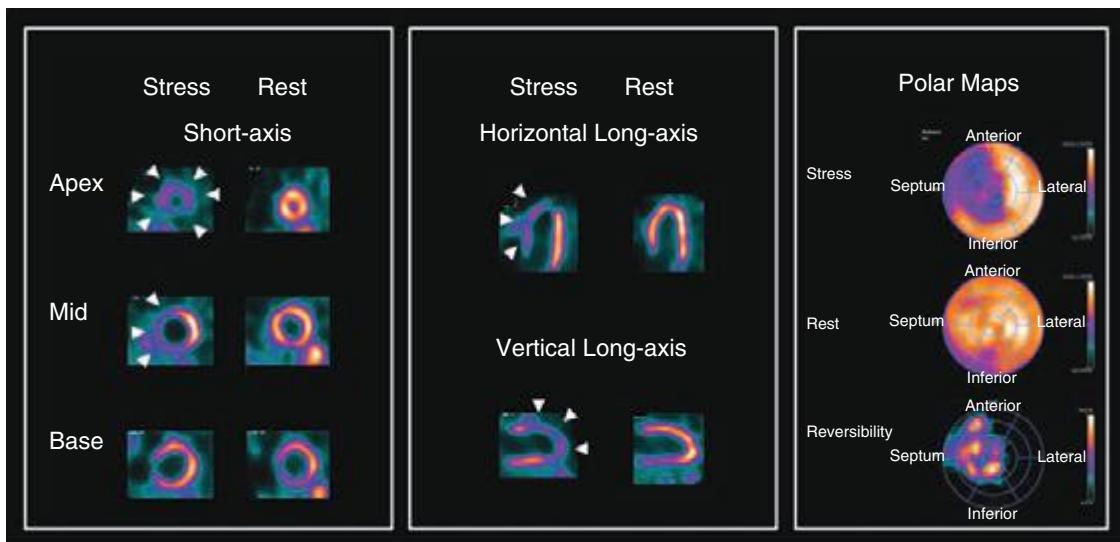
3 Exercise single-photon emission computed tomography (SPECT) myocardial perfusion technetium-99m (^{99m}Tc) sestamibi scan in a 54-year-old male with a history of coronary artery disease and a prior coronary stent. The stress images (left and middle) show a large defect involving the apex, all apical segments, mid-inferior, mid-inferoseptum, and mid-anteroseptum (arrowheads), which is completely reversible at rest (right), reflecting a large area of exercise-induced myocardial ischemia throughout the left anterior descending coronary territory. The bull's eye displays on the right panel depict the semiquantitative extent of ischemia (light yellow and blue areas represent the extent and severity of ischemia).
